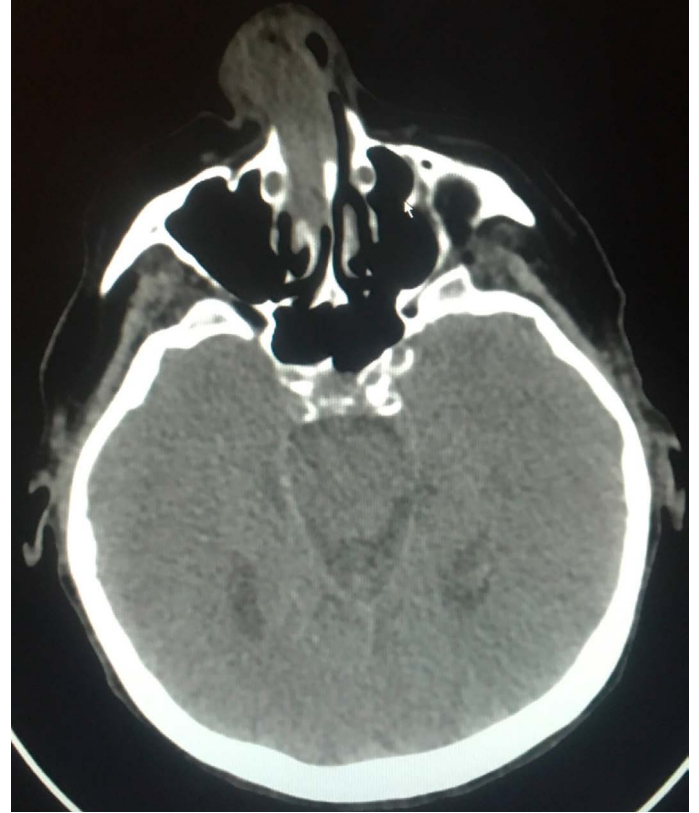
Tumor of the right nasal cavity in CT.
